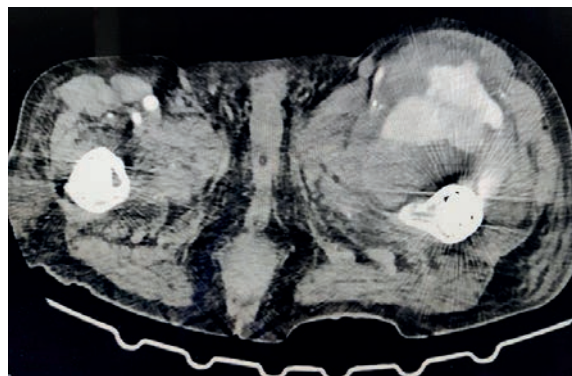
Contrast CT scan showing left deep femoral artery false aneurysm in rupture with huge thigh haematoma.
